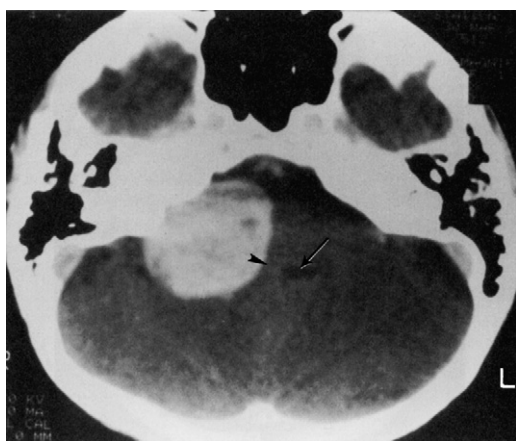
Acoustic neuroma, enhanced computed tomography. Fairly homogeneous tumor pushing the pons, cerebellar peduncle, and fourth ventricle toward the contralateral side. Fourth ventricle (*arrow*), cerebellar peduncle (*arrowhead*).
